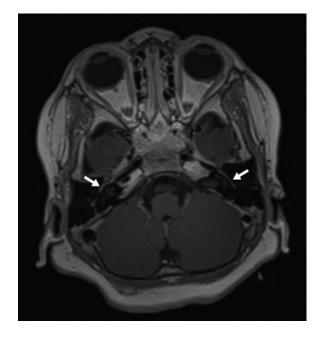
Axial T1-weighted post contrast image showing normal enhancement along the tympanic portion of facial nerve bilaterally (white arrows)
